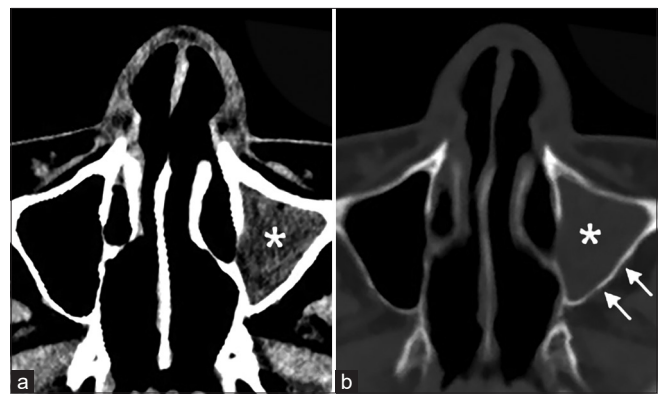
(a and b) The axial sinus CT image, the axial sinus CT image demonstrated opacification of the left frontal, ethmoid, and maxillary sinuses (*), the corresponding image in the bone window revealed diffuse thickening and sclerosis of the right maxillary sinus wall (arrow).
